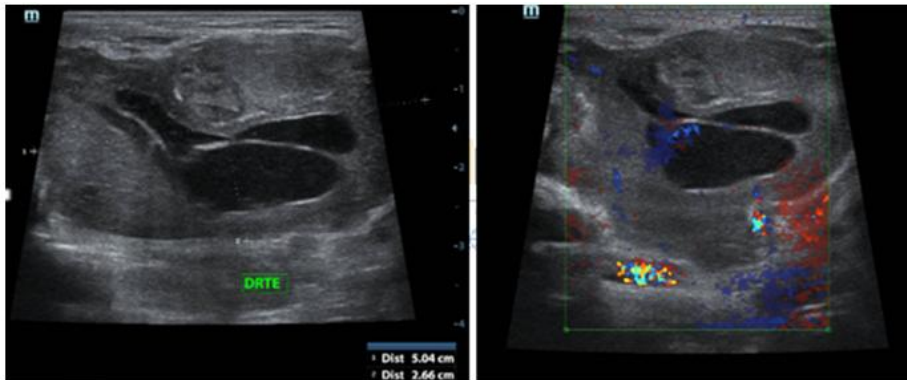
solid-cystic mass at the expense of the right parotid gland, not clearly limited, vascularized in color Doppler study.
